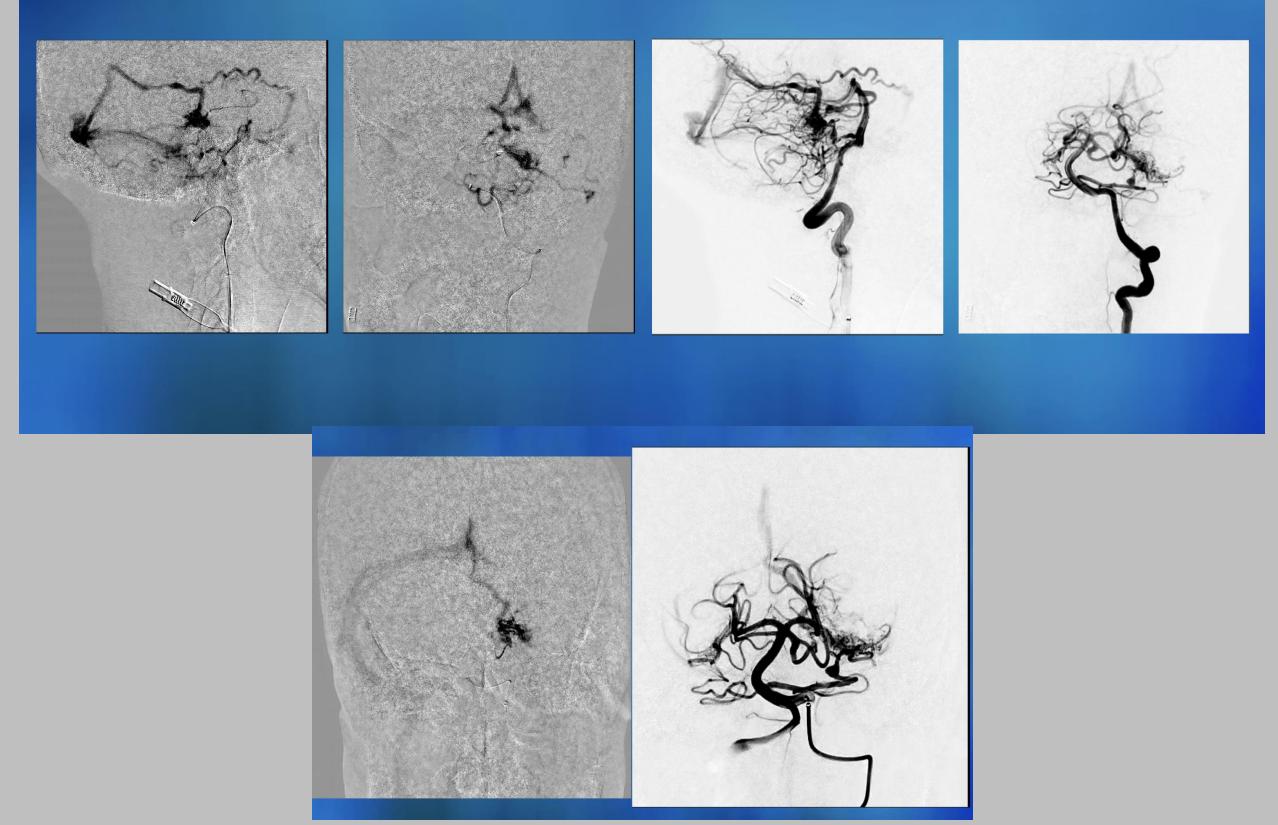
Admission CTA and cerebral angiogram of L VA (AP) Methods and Materials
